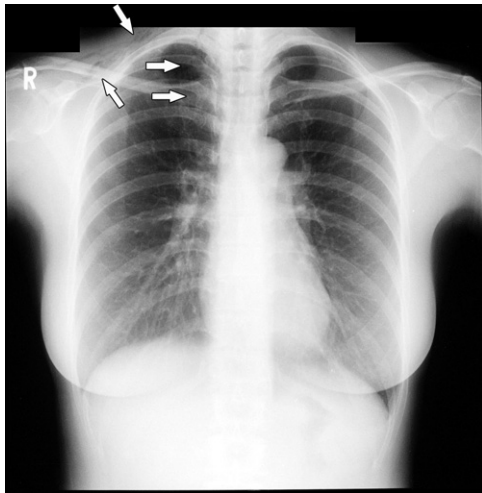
Posteroanterior chest radiograph showing subcutaneous and mediastinal air (arrows).
